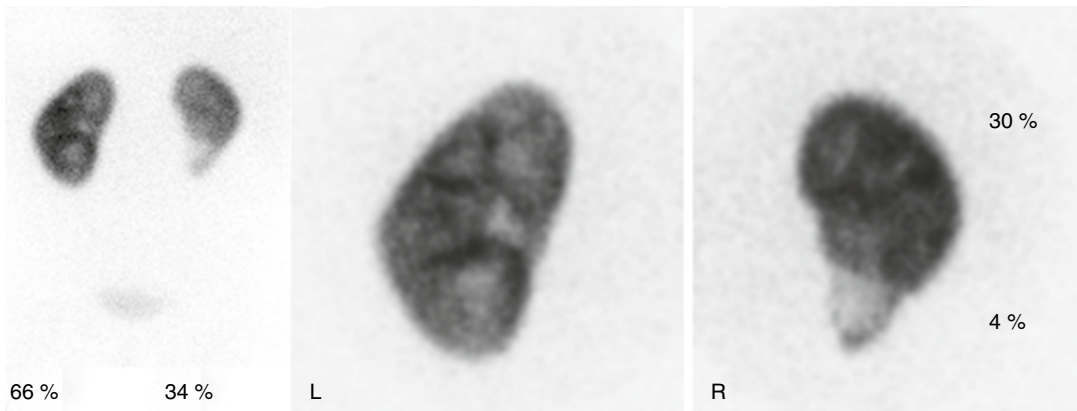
^{99m}Tc -DMSA pinhole scintigraphy in a 2-year-old girl with repeated urinary tract infections, a double right collecting system, and moderate vesicoureteric reflux in the right lower pole. Posterior images reveal reduced relative function of the right kidney. There is a large cortical in the lower moiety of the right kidney (*left*
